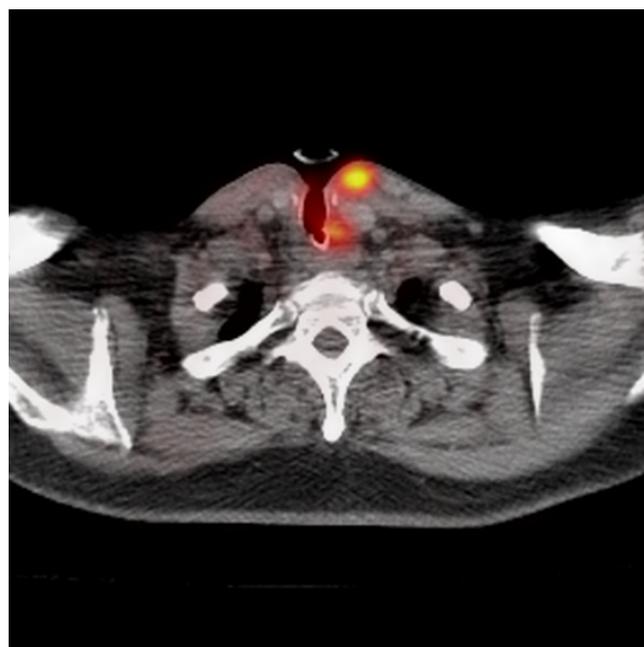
Two weeks post-radiotherapy in patient 24, transaxial ¹⁸F-FDG PET/CT images demonstrate viable tumor tissue left to the tracheostomy, in a patient with tissue changes induced by initial laryngectomy followed by chemo-radiotherapy.
